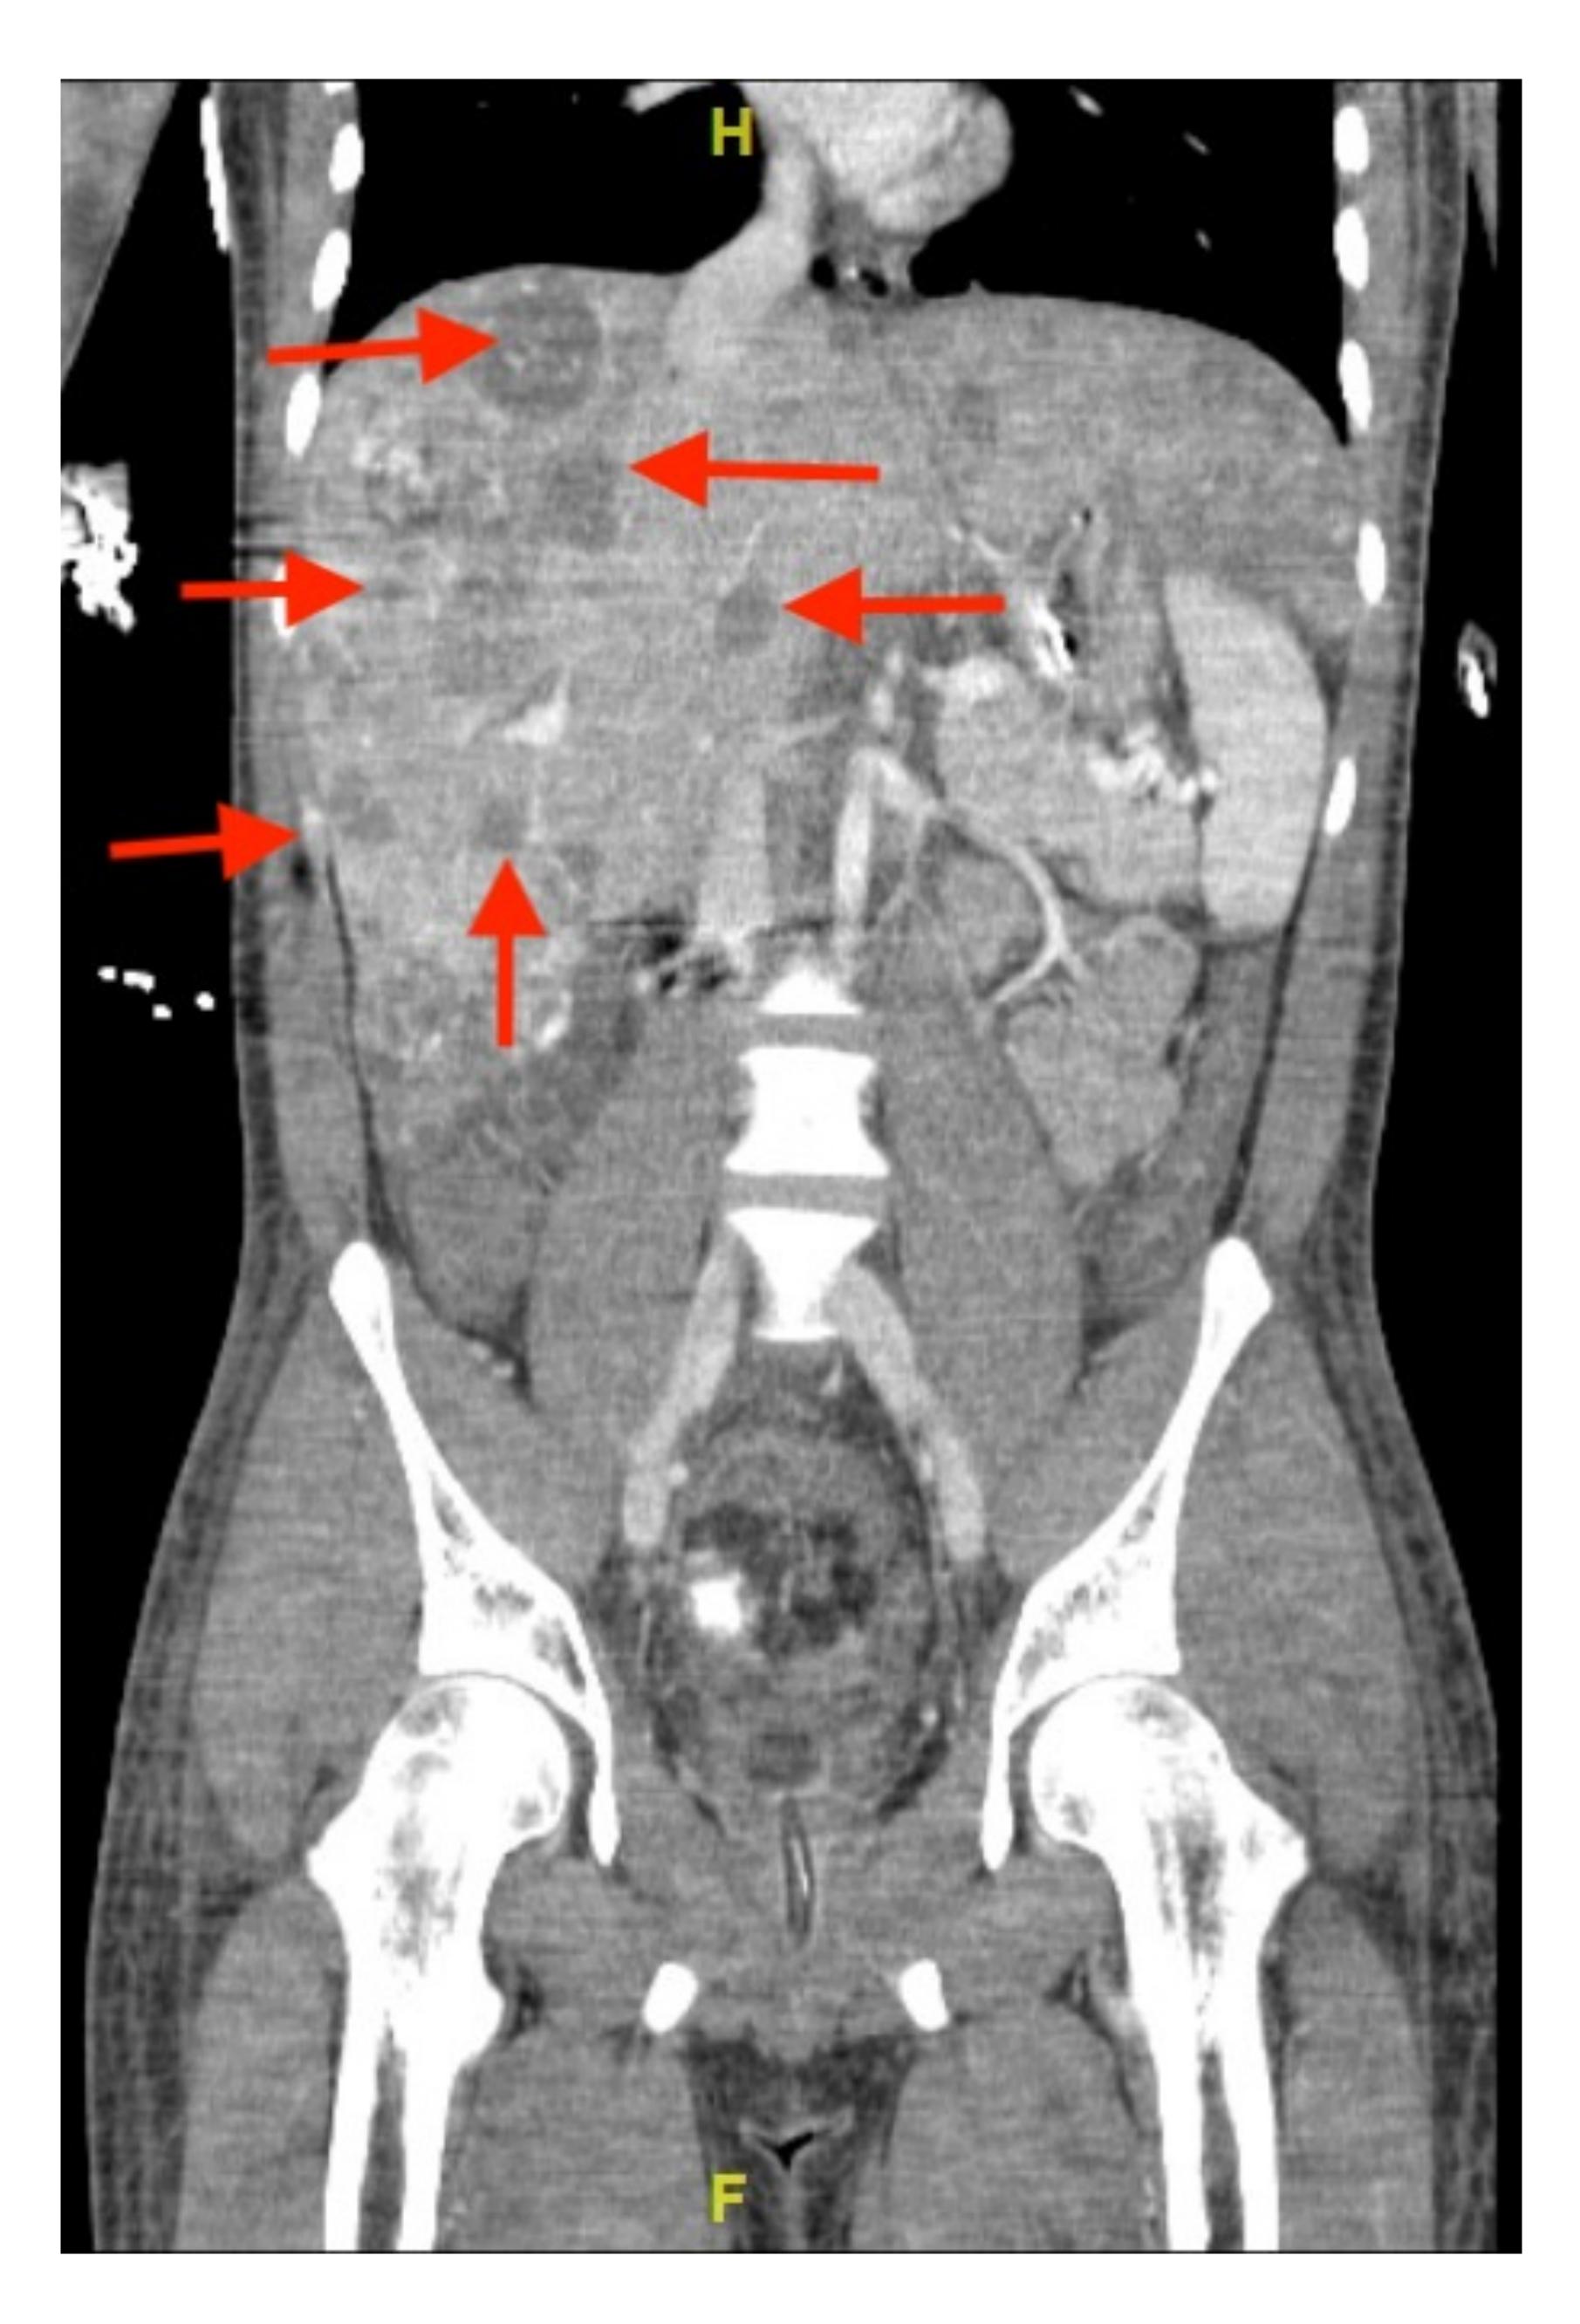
CT abdomen and pelvis demonstrating liver angiosarcomas w/ red arrows
